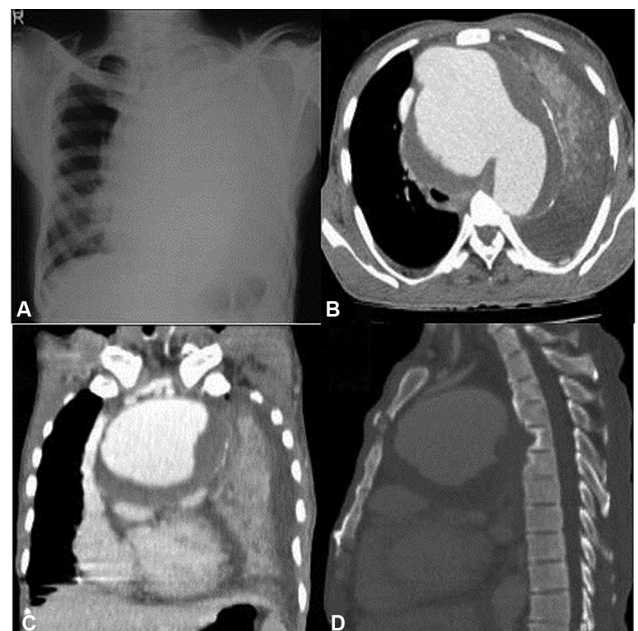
Aortic aneurysm. Frontal chest radiograph (A) in a 62-year-old male with cough and breathlessness demonstrating opacification of left hemithorax. Contrast axial (B) and coronal (C) reformatted images show intensely enhancing large aortic aneurysm with nonenhancing thrombus within. Aneurysm is noted to compress the left main bronchus resulting in collapse of left lung. Note the moderate left pleural effusion. Sagittal reformatted image (D) in bone window showing erosion of vertebral bodies by long-standing aneurysm.
